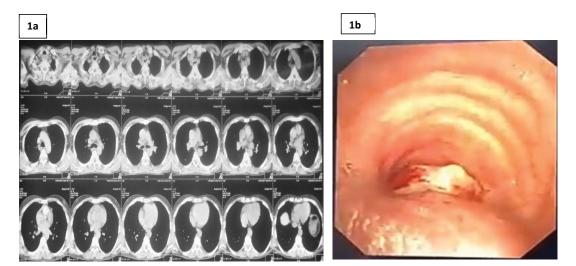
(1a) Contrast enhanced computed tomography of chest axial cut shows mass circumferentially encasing upper thoracic esophagus. The mass is seen projecting into posterior wall of the trachea and compromising the lumen of trachea. (1b) Flexible bronchoscopy showing near total occlusion of tracheal lumen by growth extending from posterior tracheal wall.
